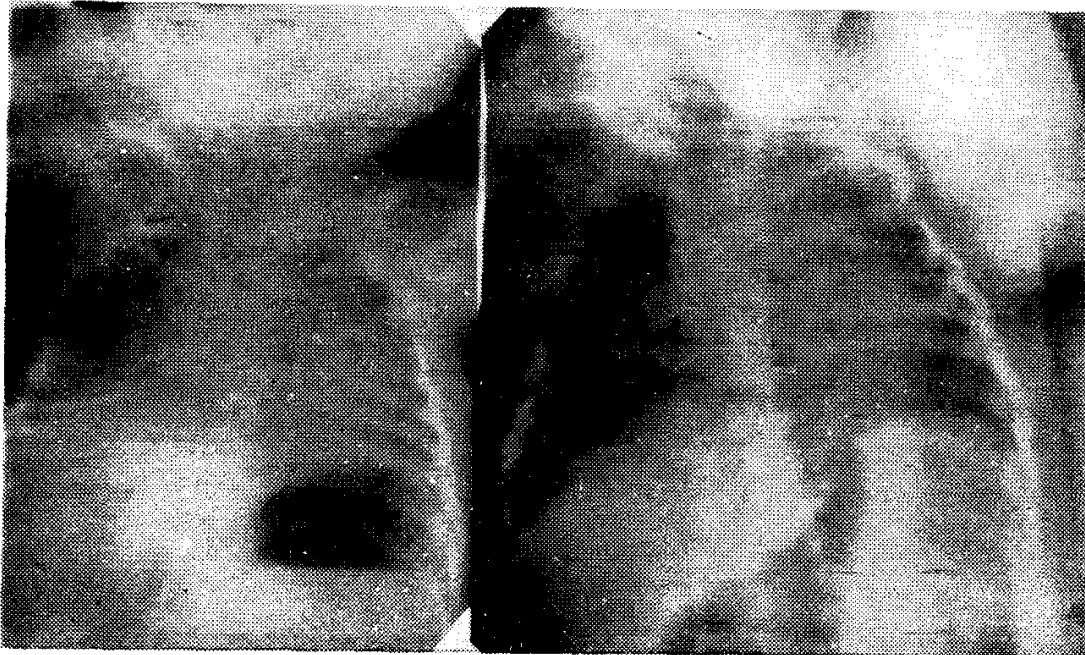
Pre and post treatment X-ray chest of Case 2. Note absence of upper three ribs on the right side.
